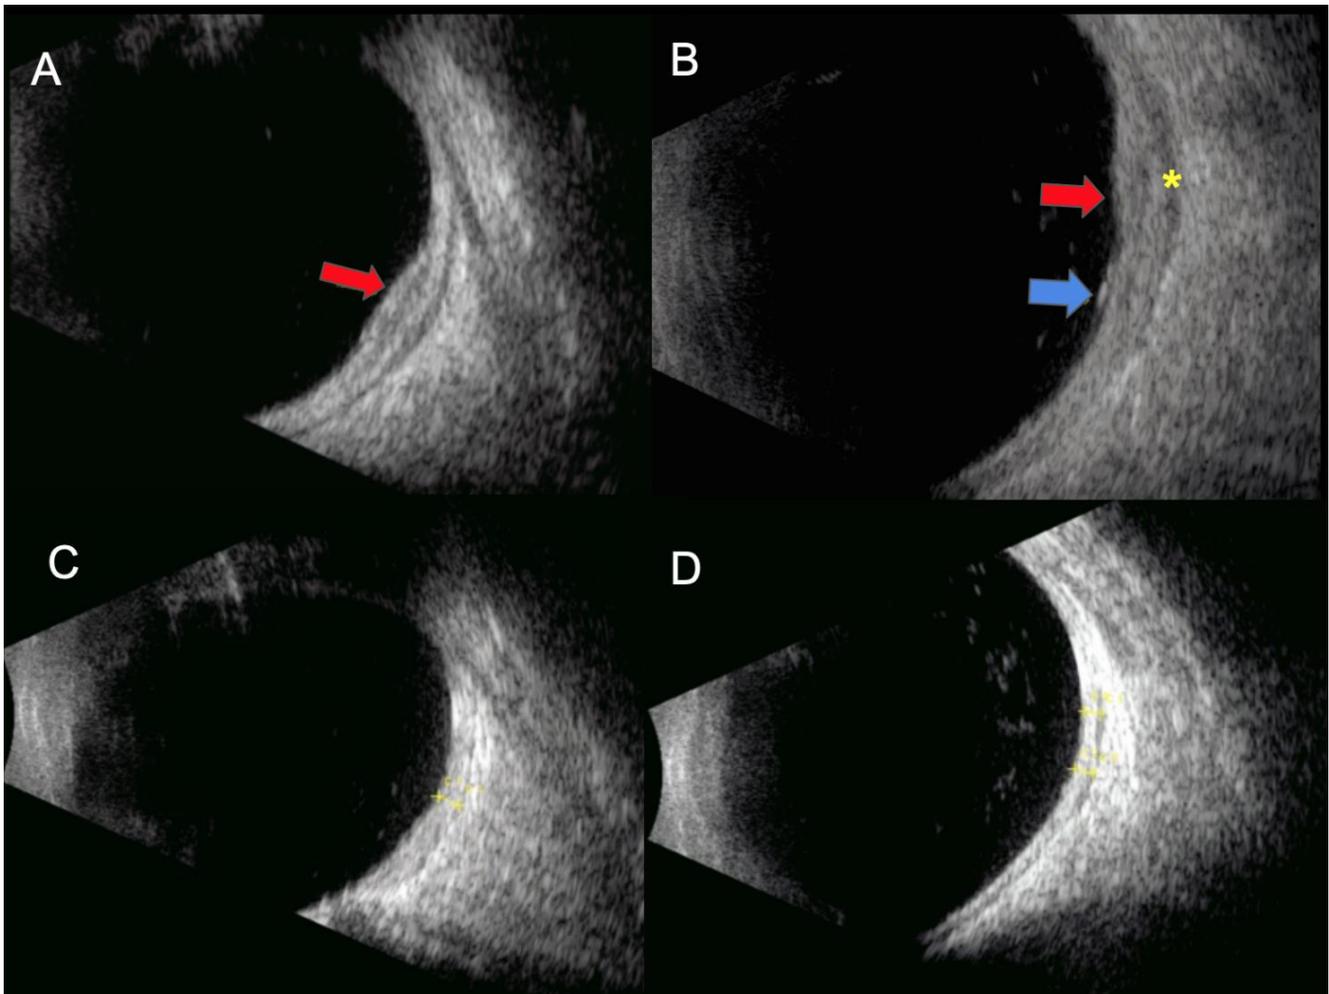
B-scan ultrasound of the left eye, pre (A,B) and post-treatment (C,D). (A,B) Temporal scans showing nodular parietal thickening (red arrow) with adjacent subretinal fluid (blue arrow) and subtenon fluid (yellow asterisk). (C,D) Regression of nodular thickening and resolution of subretinal and subtenon fluid.
